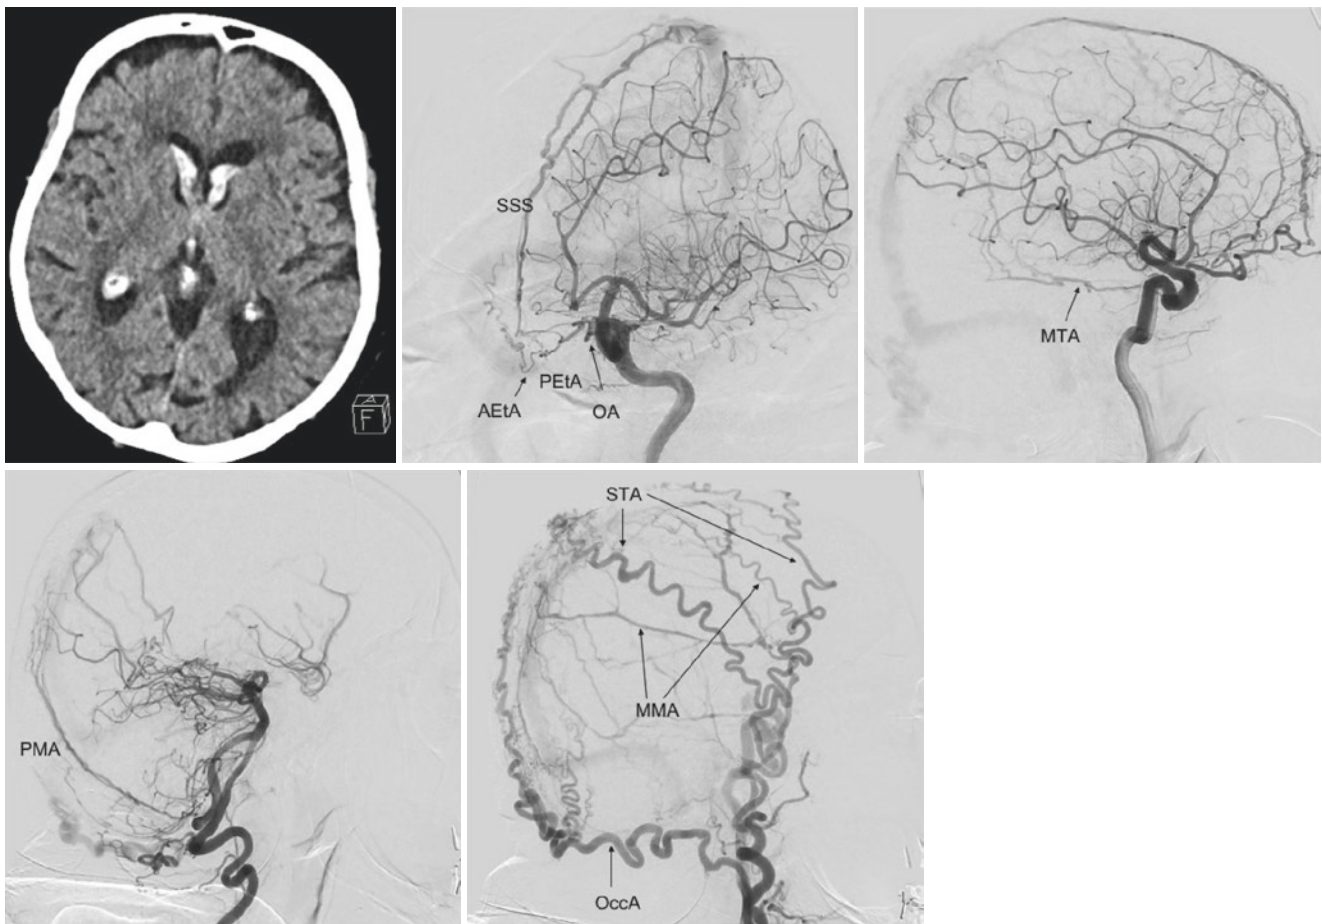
Clinical case of dural arteriovenous fistula (dAVF) fed by multiple ophthalmic artery (OA) dural branches. The figure shows the case of an 89-year-old woman, previously operated for pituitary adenoma, taken in charge for unusual headache associated with vomiting. The CT scan showed an intraventricular hemorrhage with mild hydrocephalus. The diagnostic DSA showed a complex dAVF (Cognard-Lariboisière Grade IIa + b [25]) supplied by the OA through the anterior and posterior ethmoidal arteries (AeTA and PeTA), with both direct and indirect
